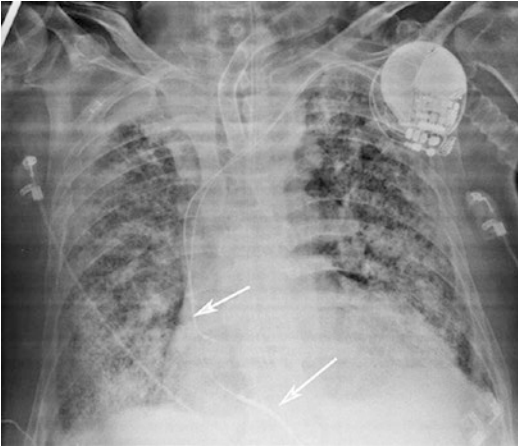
Chest radiograph shows the presence of a pacemaker (*arrows*) associated with multiple lobular, patchy, pulmonary infiltrates
